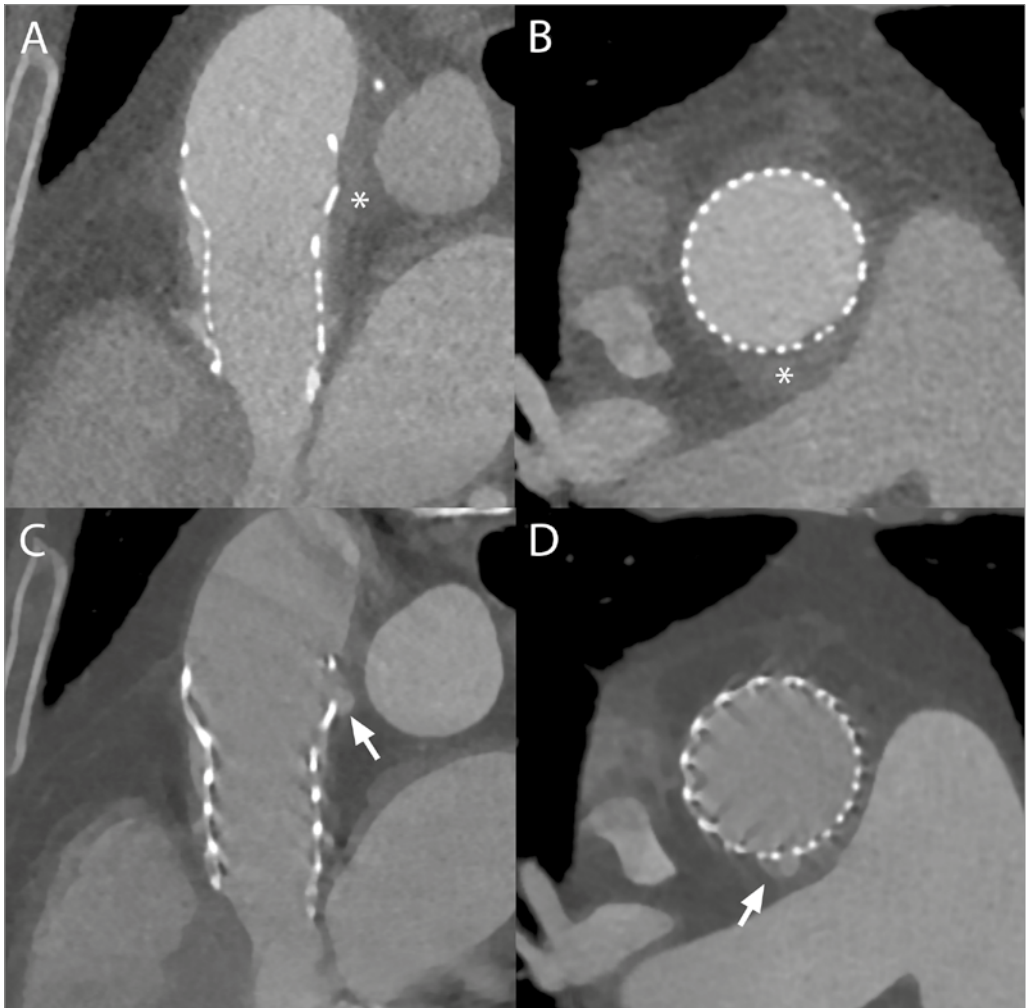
(A, B) Additional long- and short-axis CTA images of the TAVI prosthesis at presentation, showing induration (*) dorsally of the distal prosthesis. (C, D) Follow-up CTA showing a newly formed small mycotic aneurysm (ulcus, arrow) at the same localization as the earlier described stranding.
